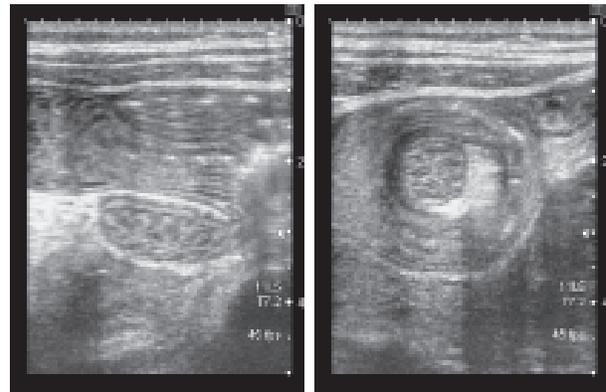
(a, b): 23 year old male patient presented with abdominal pain. Ultrasonography of the abdomen, axial image (a) shows concentric rings of bowel with echogenic fat trapped in the center s/o intussusception. Longitudinal image (b) of the same patient clearly shows the telescoping of a bowel segment into the distal segment. Twenty patients had CT scans, of which 18 were diagnosed as intussusception (90% accuracy).
